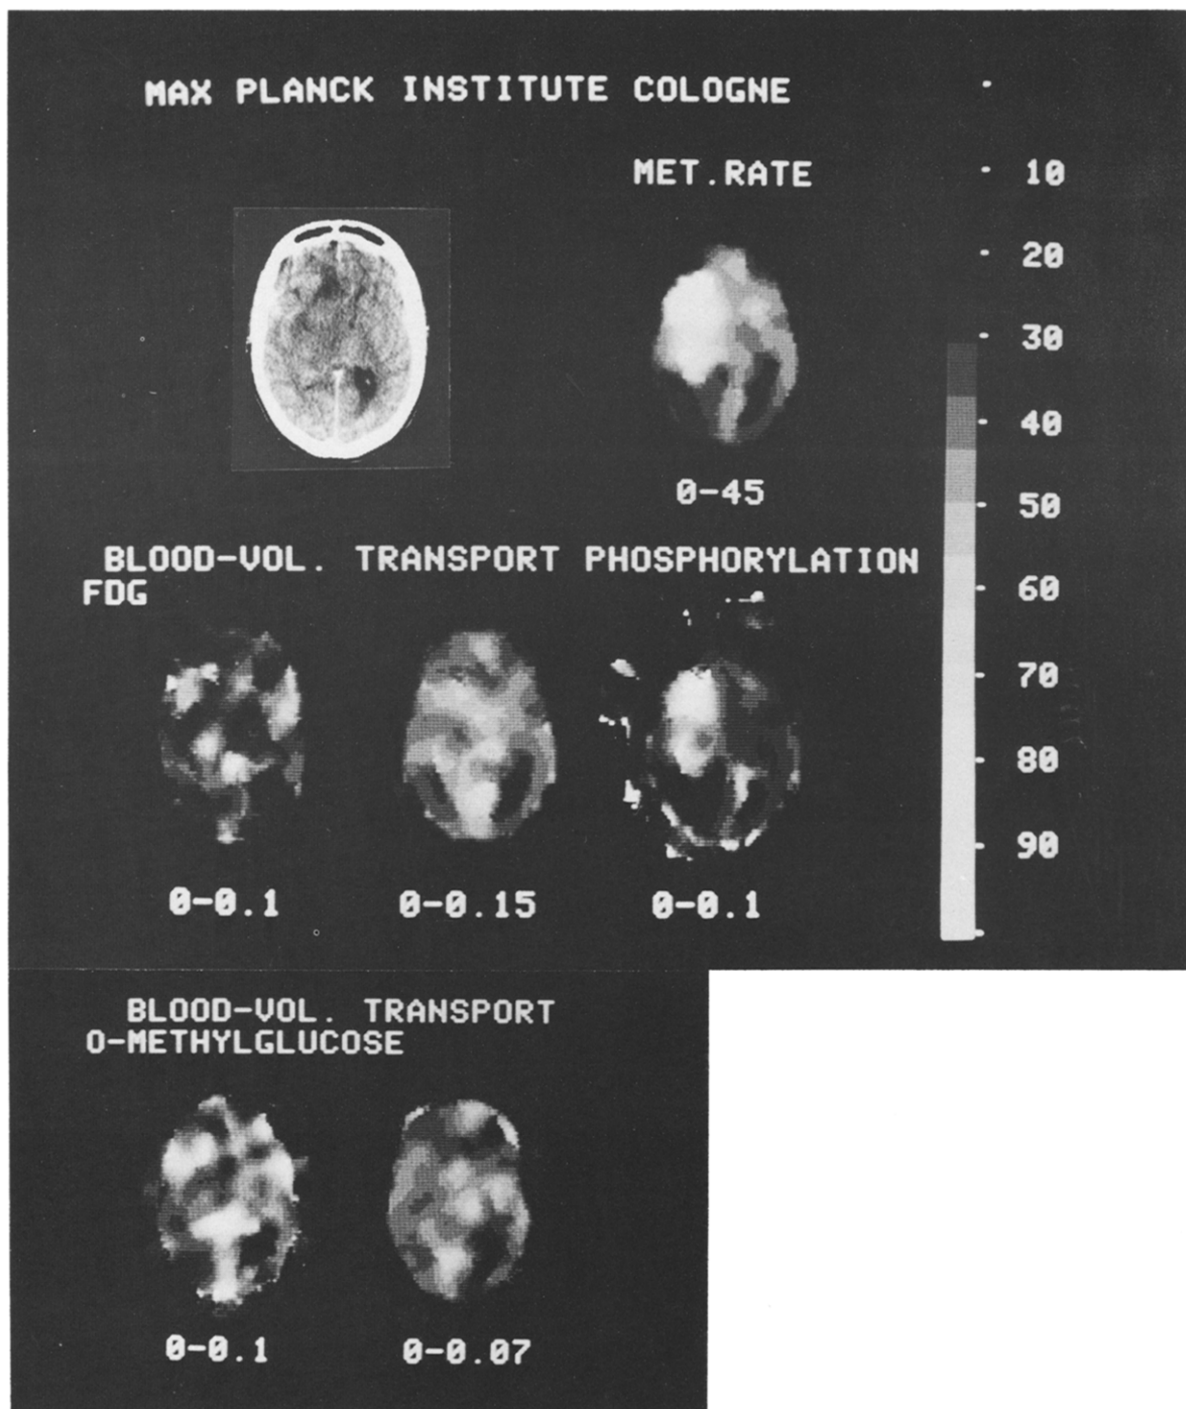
X-Ray CT (with contrast material) and parametric FDG-PET images (same arrangement as in Fig. 2) of a right fronto-temporo-parietal grade III glioma (patient 5) at 54 mm above canthomeatal plane; in addition, at the bottom row, corresponding C-11-D-methylglucose parametric images of blood volume and transport rate constant are shown. The large, non-contrast enhancing, clinically highly malignant tumor exhibits high FDG phosphorylation, e.g. in its anterior part, but normal transport of both glucose analogs. Its middle part is poorly, the anterior and posterior parts are well, vascularized.
